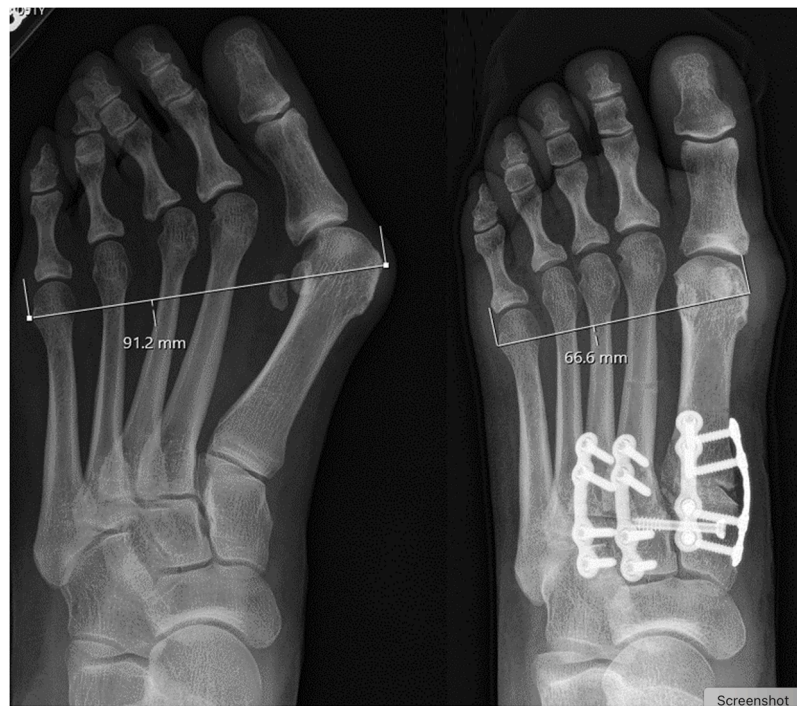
Pre-operative (left) and post-operative (right) anteroposterior plain films depicting a reduction of osseous foot width, metatarsus adductus angle, Intermetatarsal angle, 'true intermetatarsal angle and hallux valgus angle.
